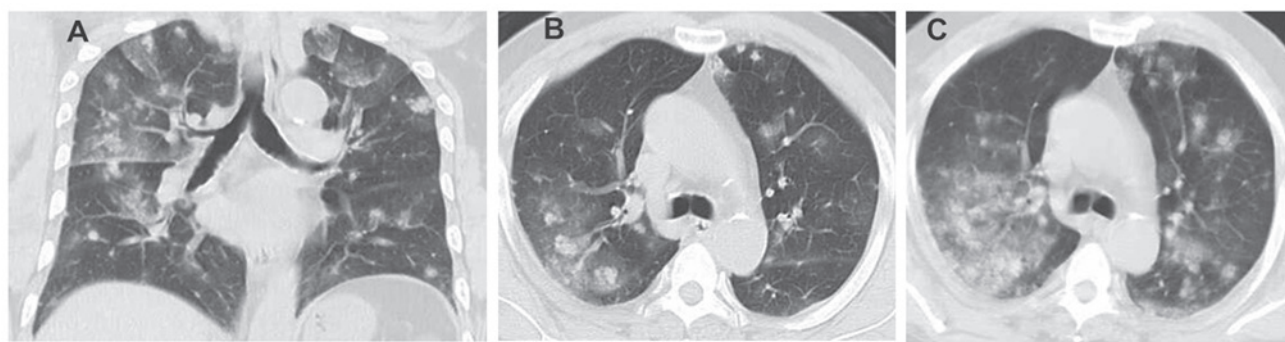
Chest CT. (A) Posteroanterior CT showing spotted or patchy shadows with obscure margins in the bilateral lung field, and no mediastinal lymph node enlargement. (B) Axial CT showing multiple low density nodules surrounded by a wide range of ground-glass-like effusions in the bilateral lung field. (C) Axial CT rechecked after 2 weeks showing more nodules with ground-glass-like shadows in extensive lung fields, indicating the rapid aggravation of the lesions compared with (A) and (B). CT, computed tomography.
